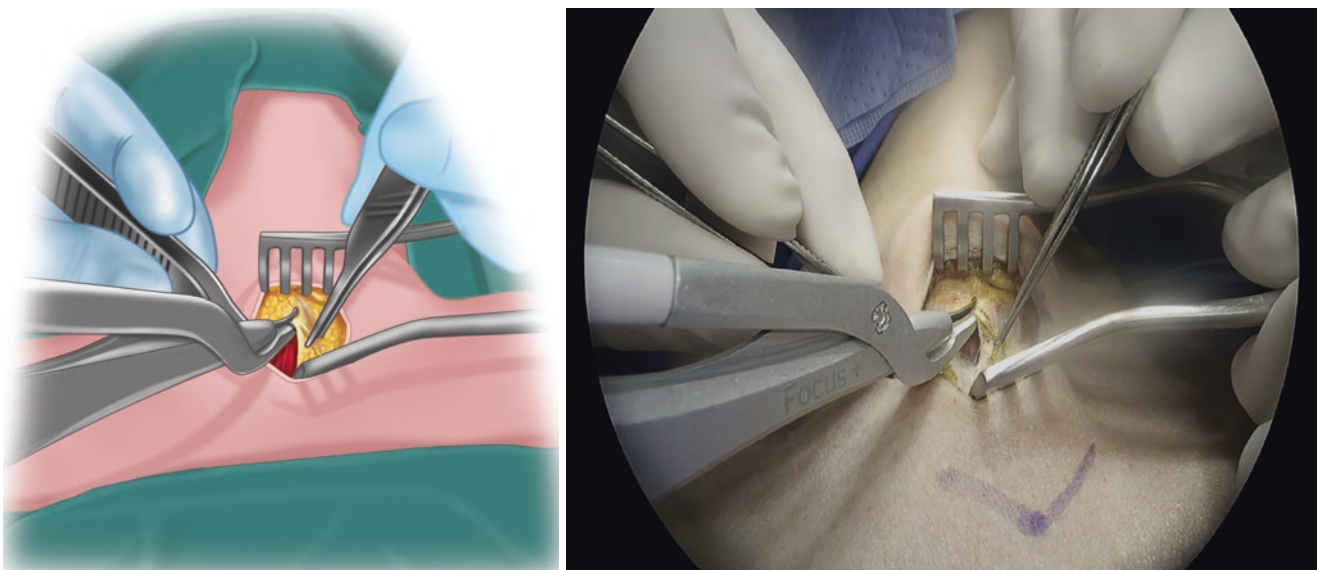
Strap muscle midline incision. The strap muscles at the midline are identified and separated using an ultrasonic energy device
